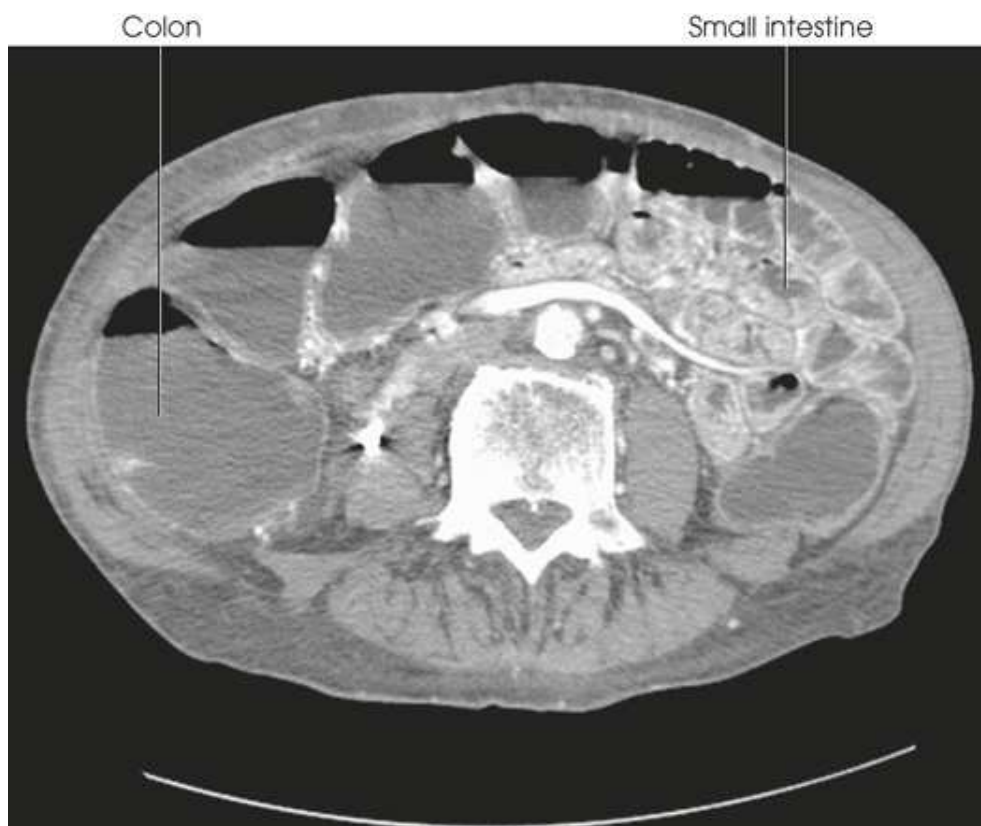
Axial CT enteroclysis with tap water and intravenous iodinated contrast medium. Intraluminal water (*dark gray*) is clearly delineated from bowel wall (*light gray*).
